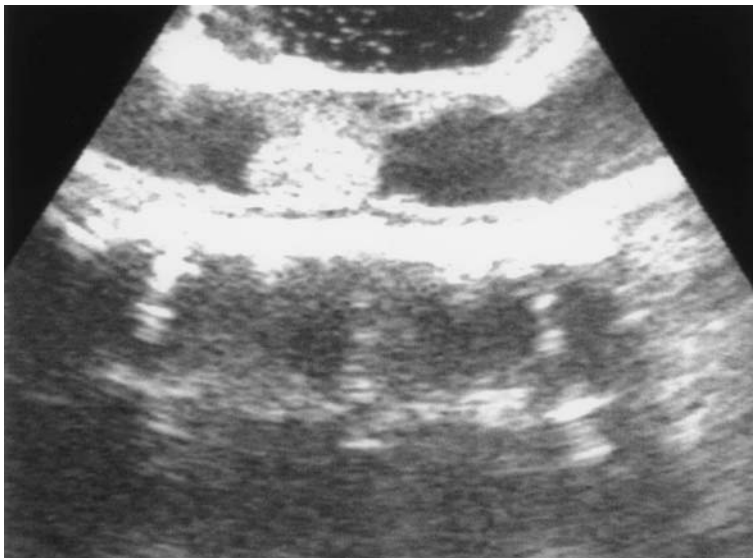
The intraoperative sonographic view of an intramedullary ependymoma allows for identification of the solid and cystic components.
